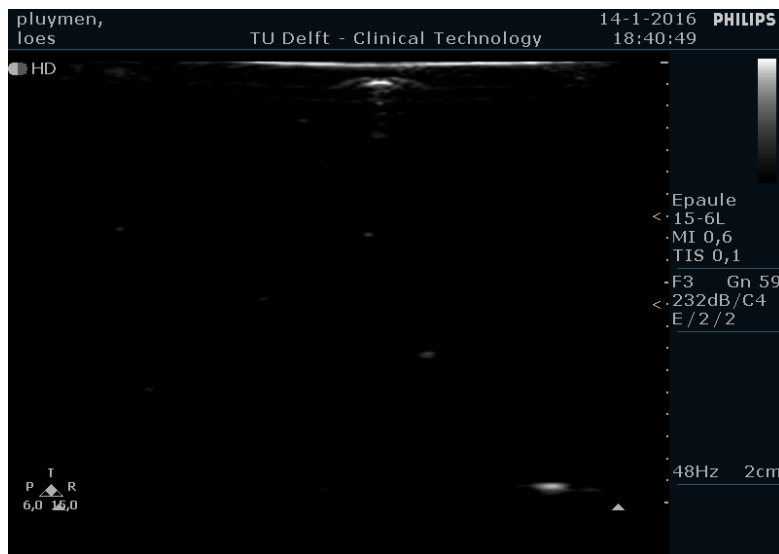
Ultrasound appearance candle gel: Images obtained with 2 cm penetration depth
